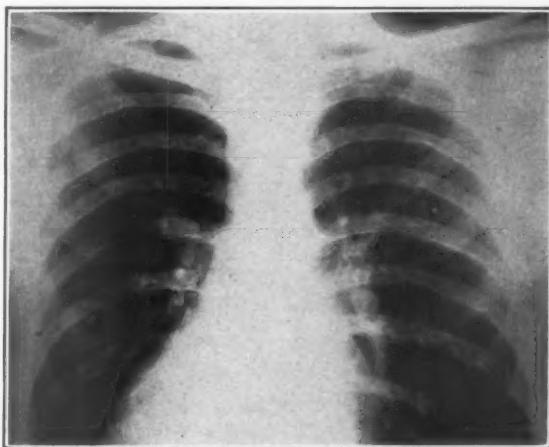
X-ray plate of chest showing left-sided hypertrophy of heart, dilatation of the ascending aorta, absence of the aortic knob, and notching of the inferior border of the ribs.
